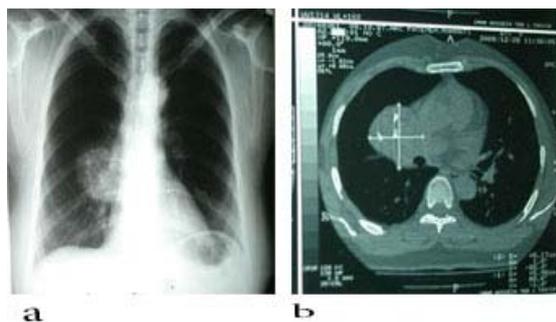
(a) Chest X-ray: A large lesion with regular margins located in the right hilar region. (b) Computed tomography scan of the chest showed a well-defined soft tissue mass in the right hilum.
